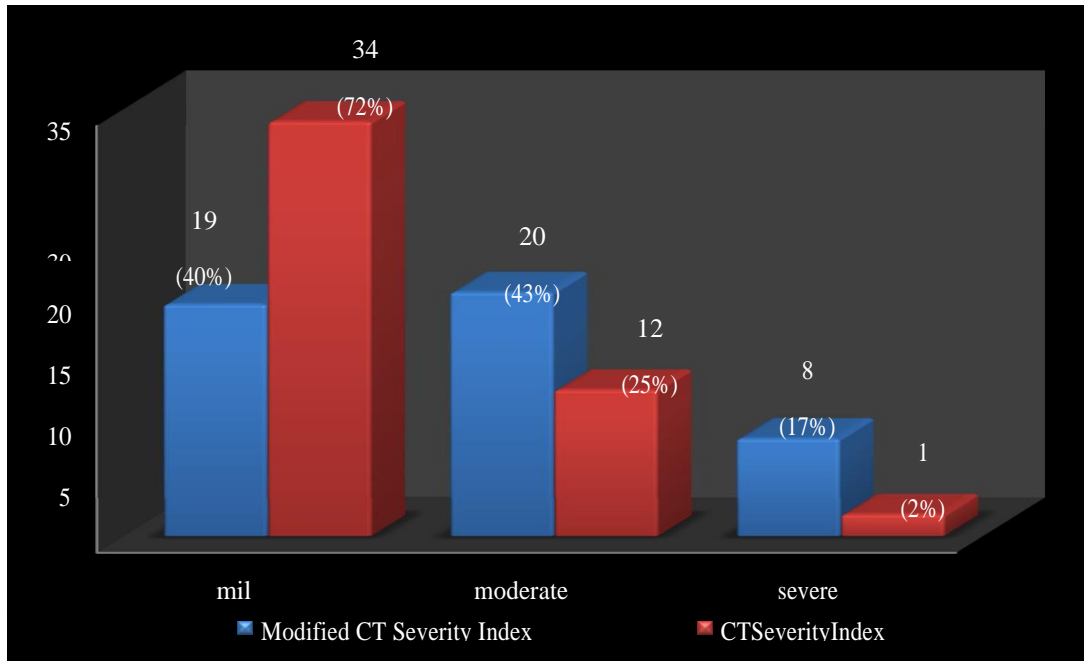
CT SEVERITY INDEX
